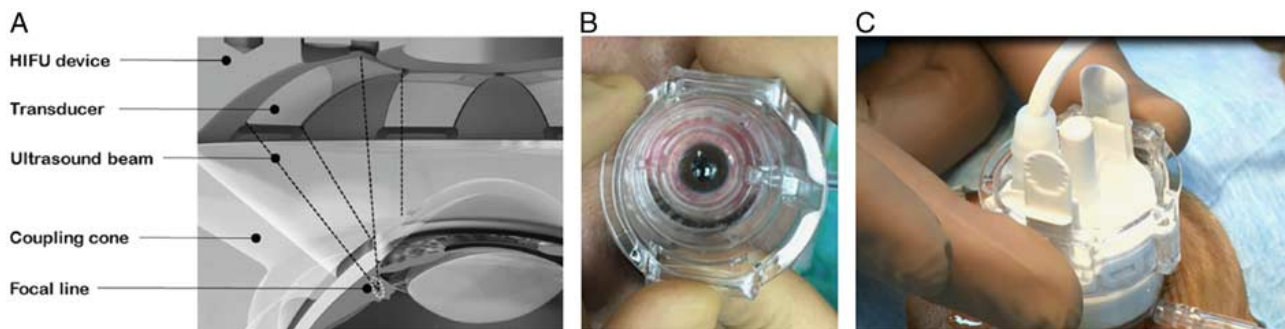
A, A piezoceramic transducer with a cylindrical segment enabling the ultrasound beam to be focused on the ciliary body. B, Placement and centering of the coupling cone. C, Probe inserted in the coupling cone; the cavity is filled with saline solution. HIFU indicates high-intensity focused ultrasound.
